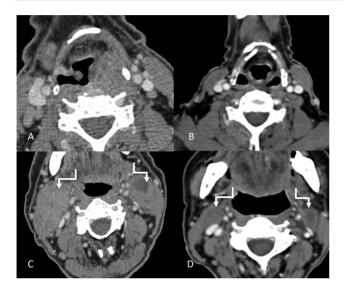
Pre-chemotherapy (A and C) and post chemotherapy (B and D) imaging of the previously shown pyriform sinus cancer. Post chemotherapy axial CT images (B and D) showing near complete resolution of the primary mass and the metastatic bilateral level II nodes (shouldered arrows).
